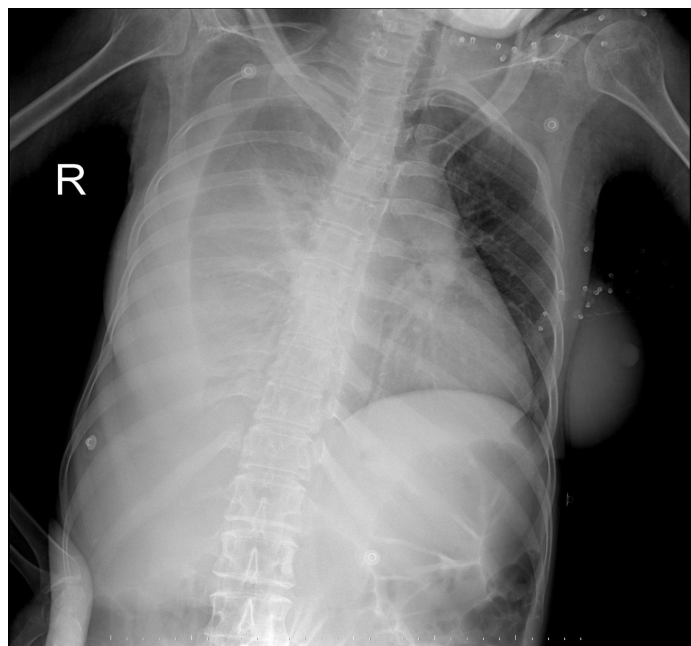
Chest X-ray taken at the time of admission to the emergency department
